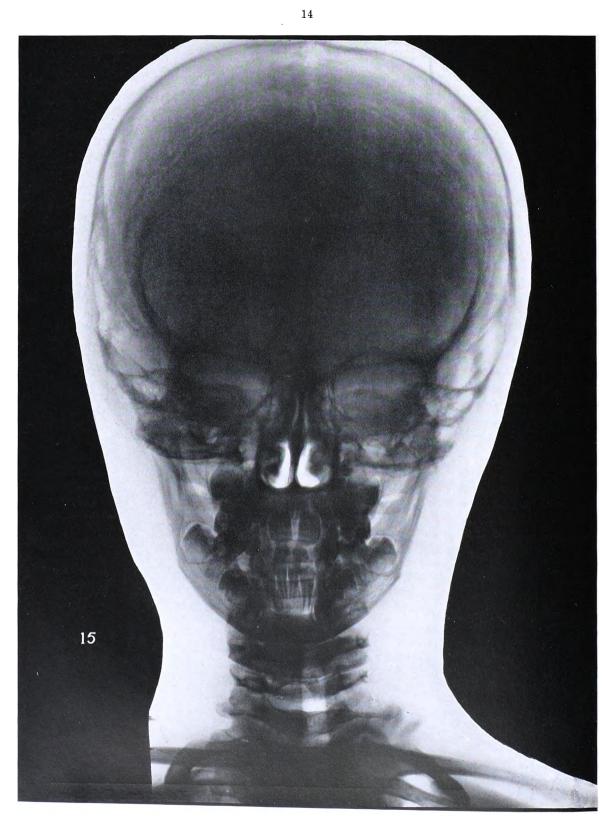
Skull: Key Radiograph. (See Fig. 58.)
